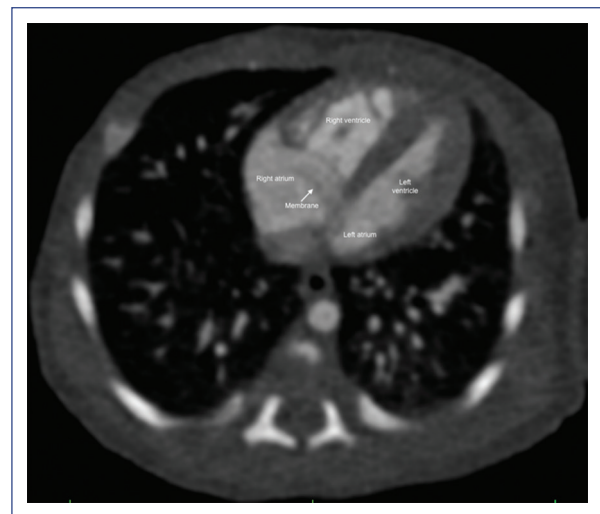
Cardiac magnetic resonance imaging, sagittal plane, showing a membrane (white arrow) in the right atrium.
